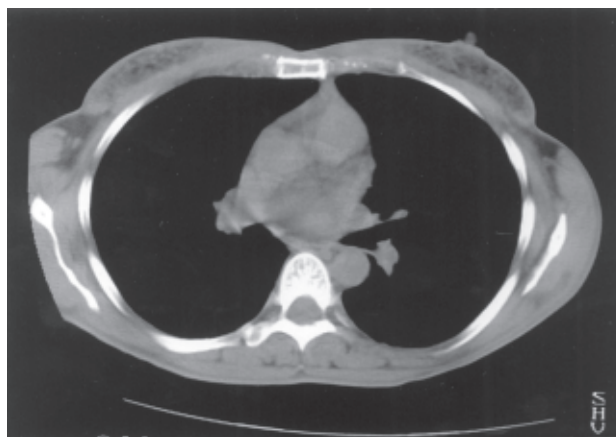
Computed tomography scan through the mid-chest shows minimal subcutaneous fat.
